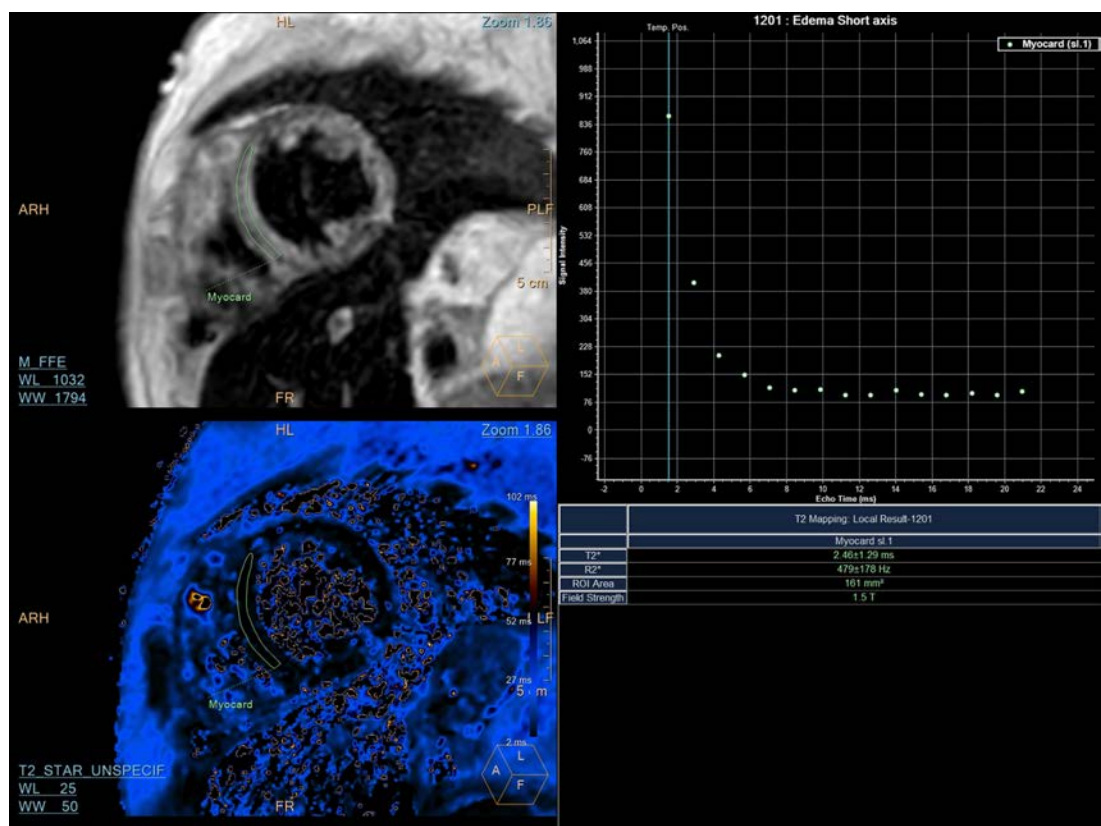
Cardiac magnetic resonance imaging T2 star sequence.
